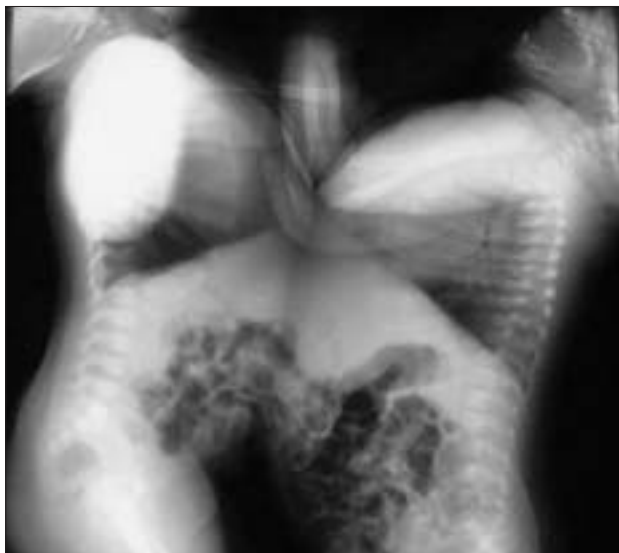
X-ray showing twins joined at the liver.
